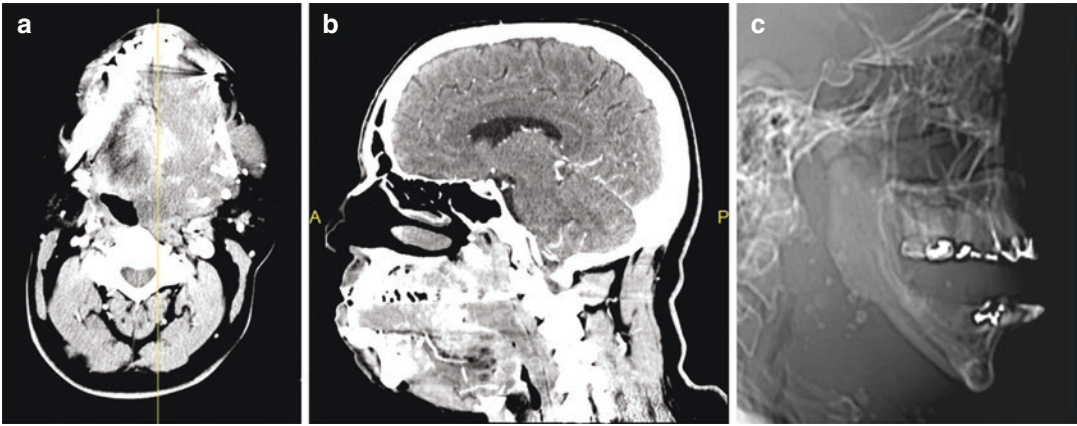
(a, b) Axial and sagittal CT images show expanded tongue, submental, and submandibular VM with anterior displacement of left mandibular body and airway deviation to the right. Arrow denotes phlebolith
